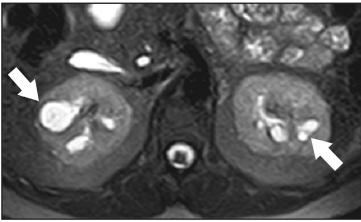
Medullary cystic kidney disease (MCKD) in a 42-year-old woman with suspicious clinical and laboratory findings. Axial T2-weighted MR image demonstrates bilateral normal-sized kidneys with multiple cysts in the medulla (arrows) suggestive of MCKD.
